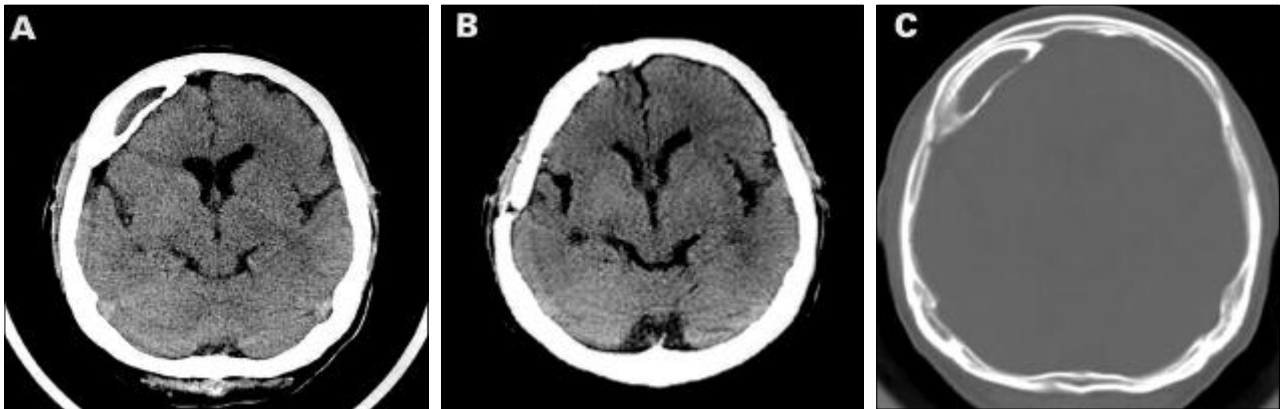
(A,C) Preoperative CT scan showing an ossified subdural mass in the frontoparietal region. Note that the mass has hyperdense outer and inner rims and a slightly hypodense central part. (B) Postoperative CT scan obtained one month later showing complete disappearance of the mass.
